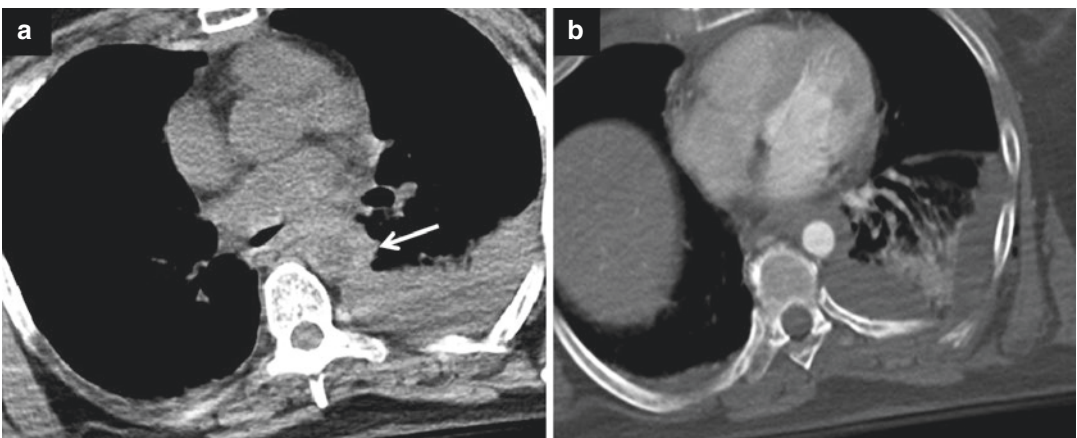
Post-traumatic intramural aortic hematoma (see also rib fracture and pleural effusion). (a) CT axial non-contrast image show (*white arrow*) high attenuation material into aortic wall; (b) postcontrast image
